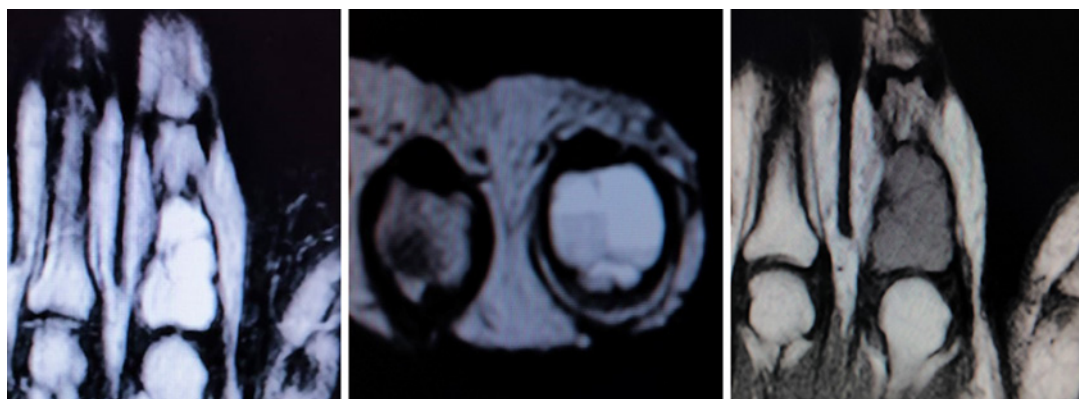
MRI showing T2 coronal and axial sections showing hyperintense lesion. T1 section shows hypointense lesion. Fluid-fluid level is noted in the axial section and multiloculated lesion noted in the coronal sections. MRI, magnetic resonance imaging.
